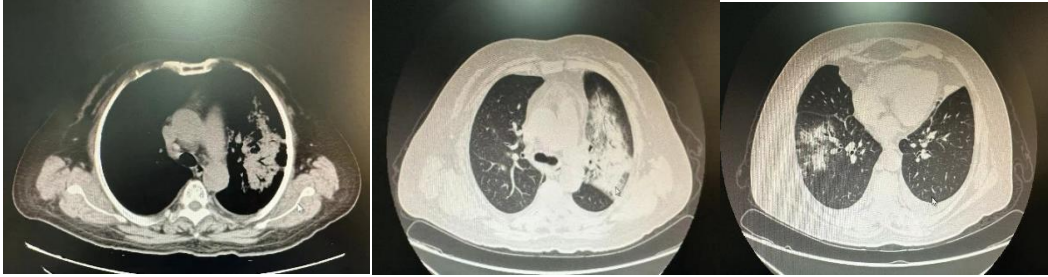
Chest CT image of the patient upon admission on October 15, 2023.
